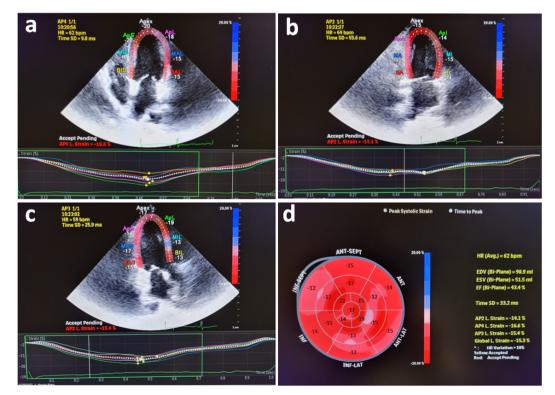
An example of left ventricular global longitudinal strain speckle tracking of a patient from the apical 4-chamber (A), 2-chamber (B), and 3-chamber (C) views. (D) The bullseye view of 17 ventricular segments from the apical 4-chamber, 3-chamber, and 2-chamber views.
